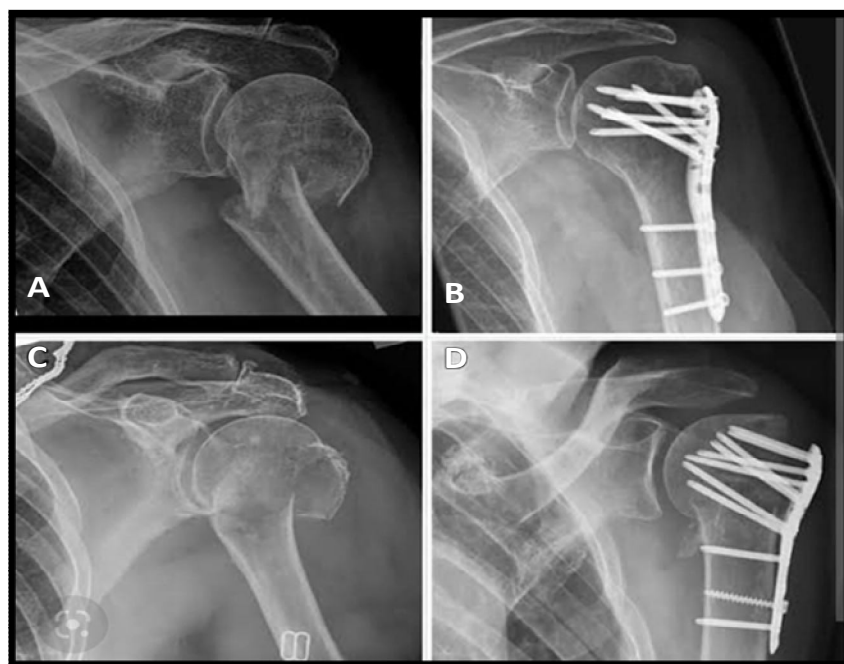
Preoperative and post-operative X-ray images with Synthes proximal humerus locking plate
